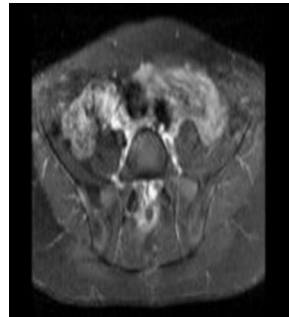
Post-operative MRI of the lumbosacral vertebrae; there is no evidence of tumor recurrent.
